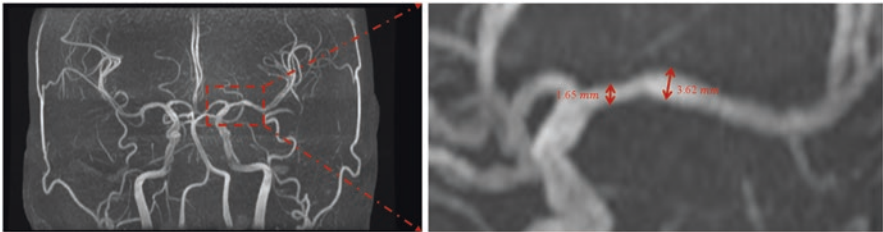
MRI of the patient cerebral arteries with 55% area reduction stenosis [27]
